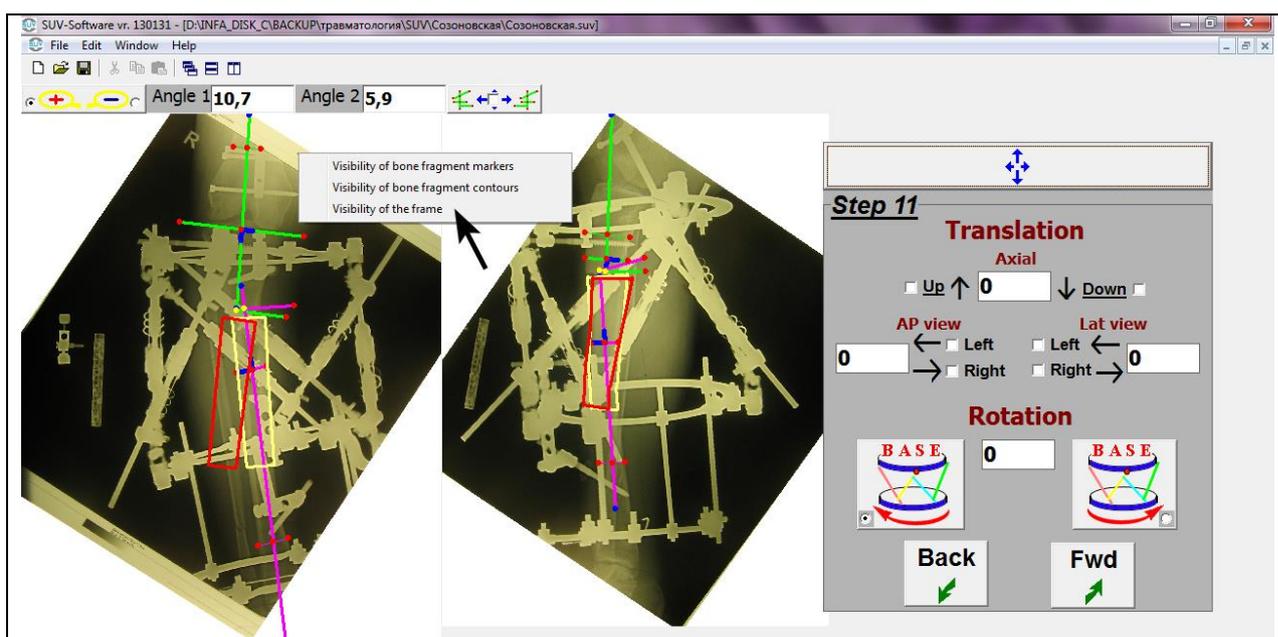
Ortho-SUV program window in Step 11. There are bone fragment markers (trees) and yellow and red bone contours in field of roentgenograms. Yellow bone contours are initial position of mobile fragment; red bone contours are final mobile
